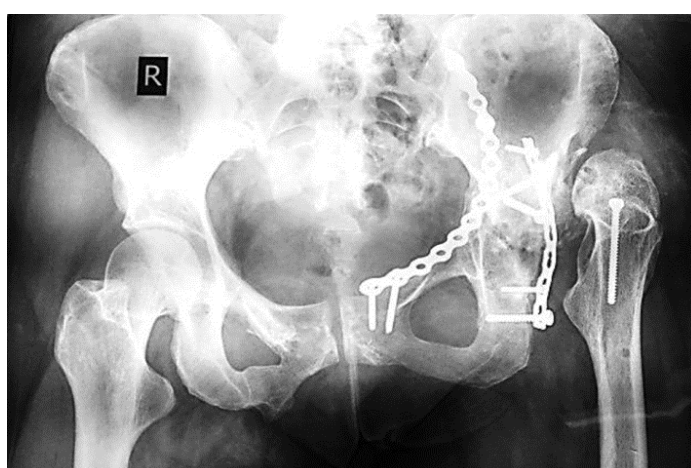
Radiograph of pelvis and the hip joints of the 32-year-old female patient T. showing bone fixation at the first stage of treatment
